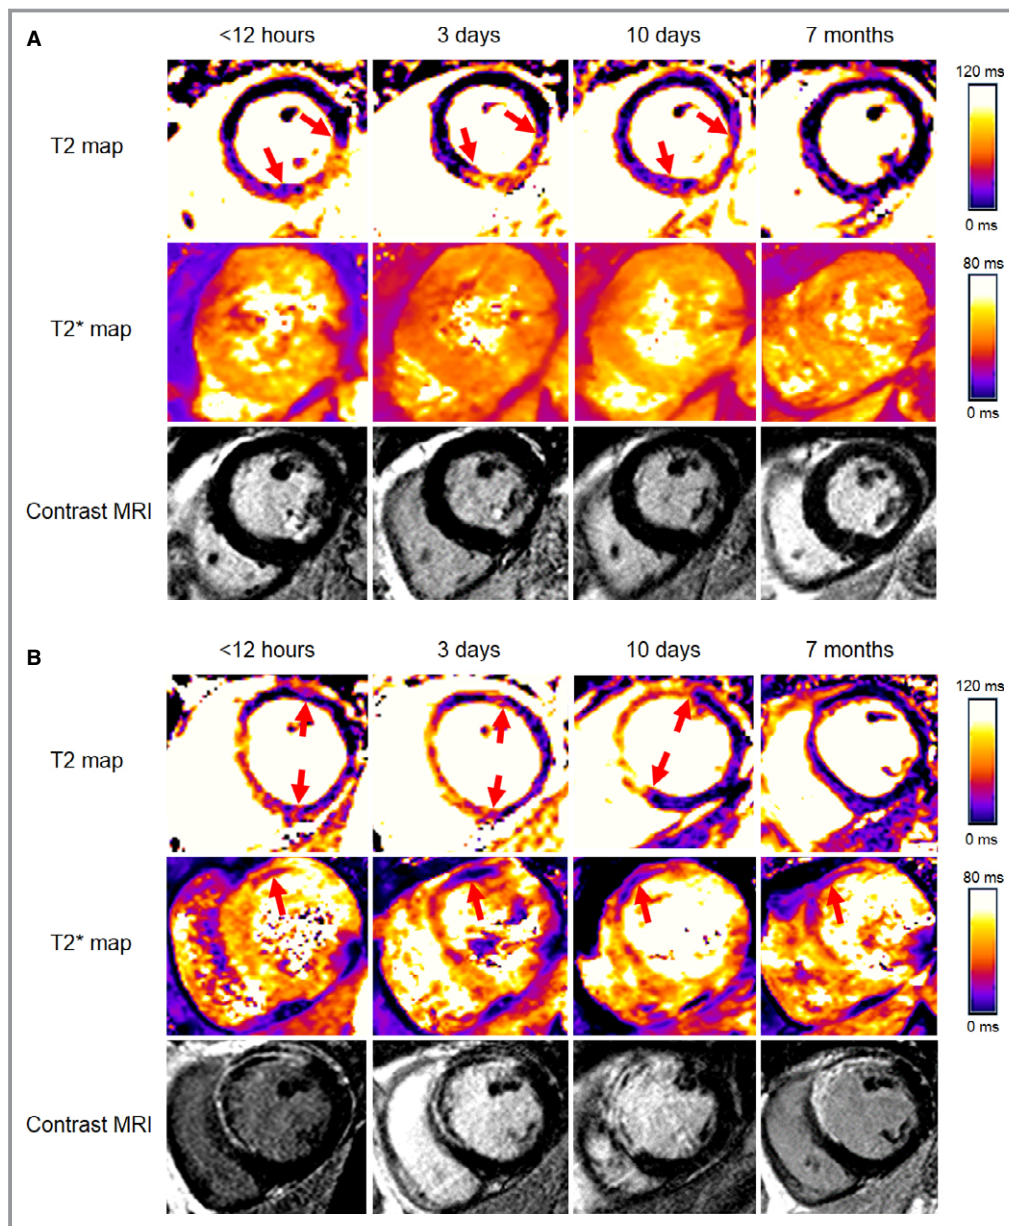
Cardiac magnetic resonance T2 mapping, T2* mapping, and contrast-enhanced images at 4 time points after reperfusion from patients without (A) and with (B) myocardial hemorrhage, following emergency percutaneous coronary intervention (Data S2). MRI indicates magnetic resonance imaging.
